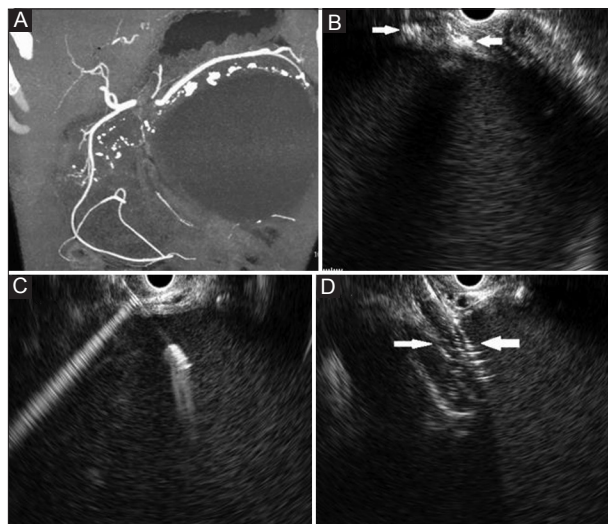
(A) Large pseudocyst with calcific specks in its wall. Parenchymal calcification in the head is also noted. (B) Endoscopic ultrasound (EUS): Large pseudocyst with calcification in the wall (arrow). Posterior acoustic shadowing is also seen. (C) EUS-guided needle puncture of the pseudocyst. (D) Dilatation of the tract by balloon under EUS guidance (arrows)
